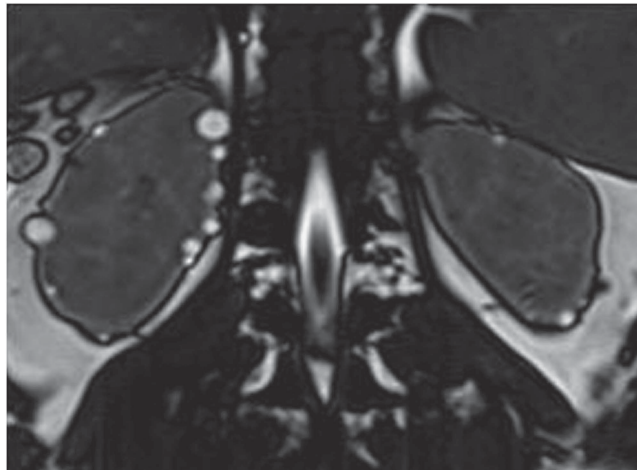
Magnetic resonance images of the index case showing bilateral renal cysts.
